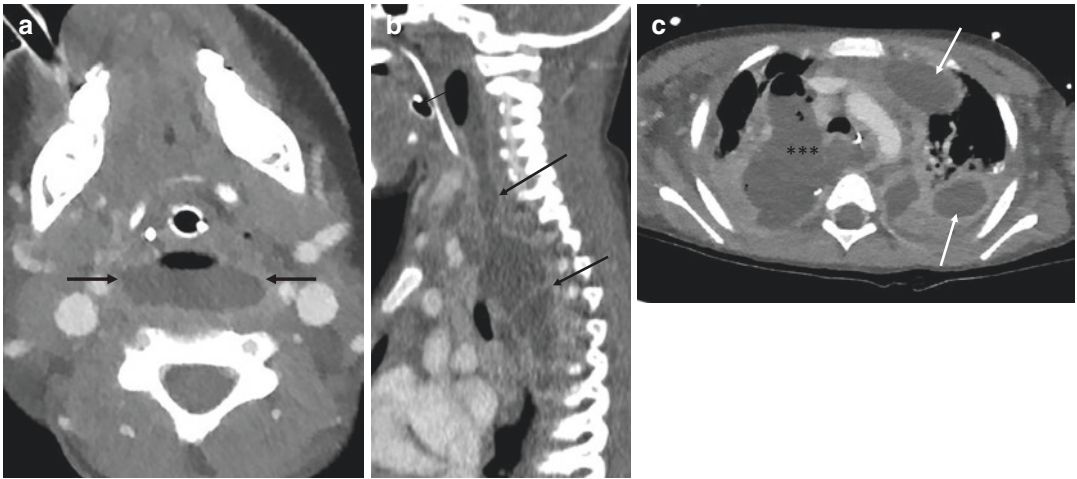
(a) Axial CECT neck. Endotracheal tube and nasogastric tube are visible in the oropharynx. There is a fluid and gas containing collection in the retropharyngeal/danger space (black arrows). (b) Sagittal contrast enhanced CT off midline showing a rim enhancing
